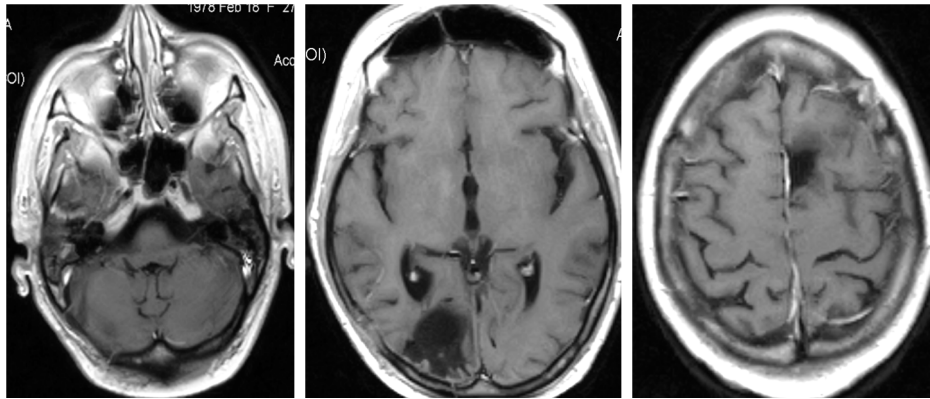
Case 1 - MRI T1 Gadolinium-control at 1 year - no enhancement
